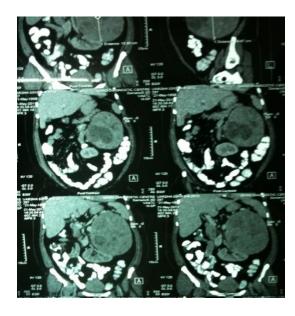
Contrast enhanced CT scan of abdomen showing left adrenal mass
